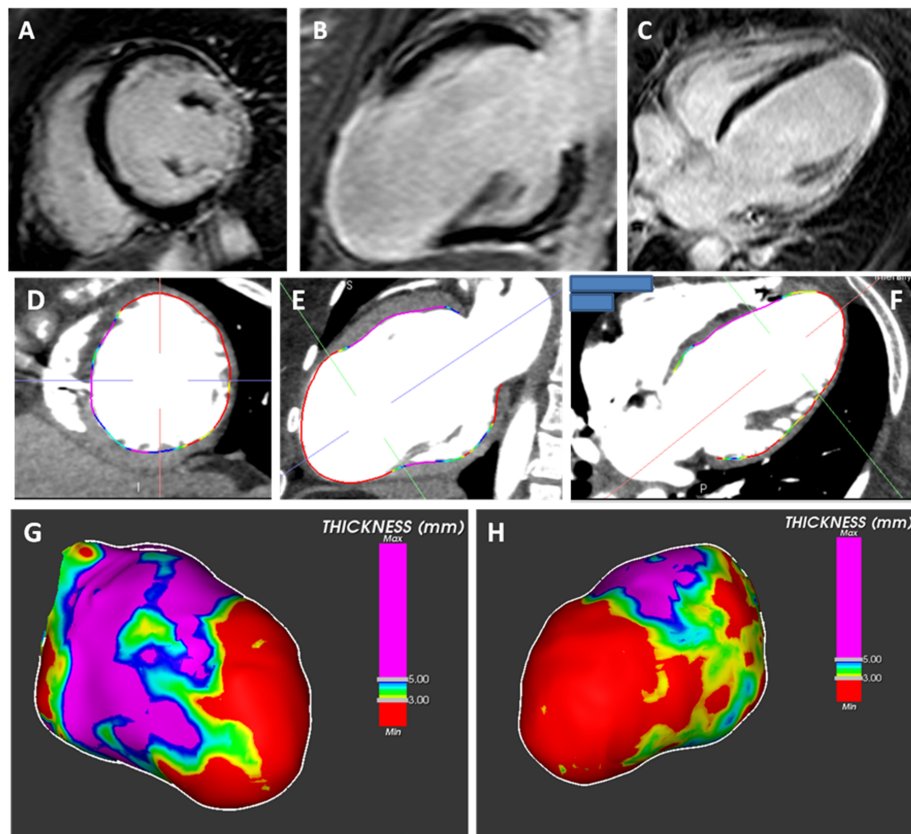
Myocardial abnormalities are analysed by different techniques. Panels A–C from CMR show transmural LGE in the lateral and apical walls, with extension to the apical segments of the anterior and inferior wall. Panels D–F from computed tomography show severe wall thinning in the same segments where LGE is present at cMR; the coloured line is the endocardial border drawn with the ADAS 3D software. Panels G and H show the 3D reconstruction of the cardiac computed tomography, with severe wall thinning (<3 mm, coloured in red) in the apex, lateral wall, and antero-apical segment; only the basal and mid portion of the septum and the anterior wall have a wall thickness >5 mm.
